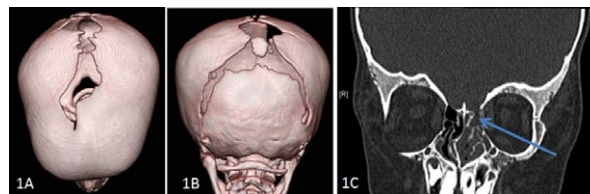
(A and B) Three-dimensional reconstruction of cranial CT scans of the patient showing open anterior (A) and posterior (B) fontanelles. (C) Coronal section of the CT scan showing the 3.8 mm defect in left cribriform plate.
